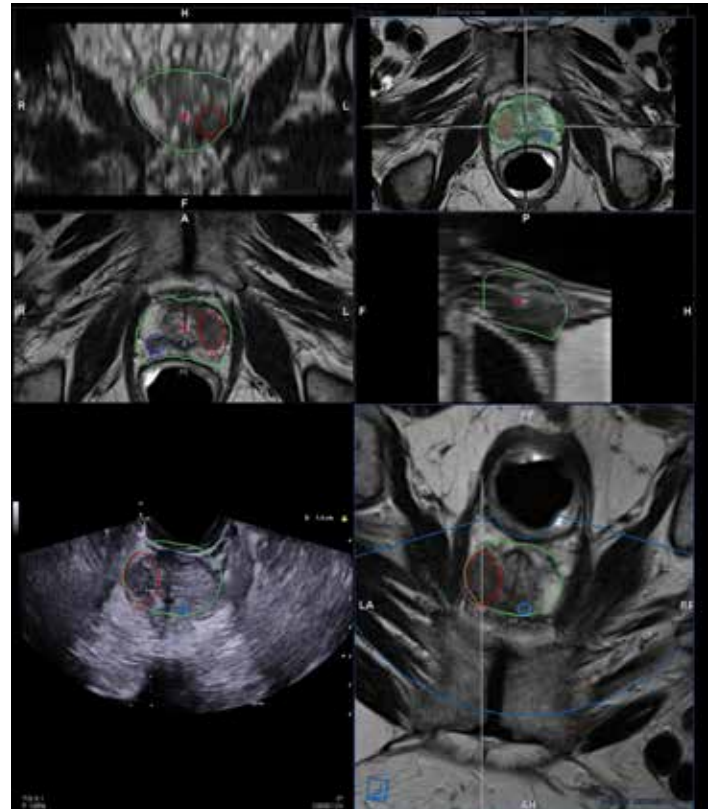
In this case the MRI examination of the patient reports a PIRADS 5 lesion on the equatorial zone on the left side of the gland and a PIRADS 4 lesion in the contralateral position. Thanks to the possibility of multiple targeting geometries, the doctor can plot the contours of the lesions more efficiently. The contours of the prostate can be used as a benchmark to monitor prostate movements and as support for the alignment. The doctor takes 2-3 samples from the targeted region using the biopsy guide as support to reach it more precisely.
